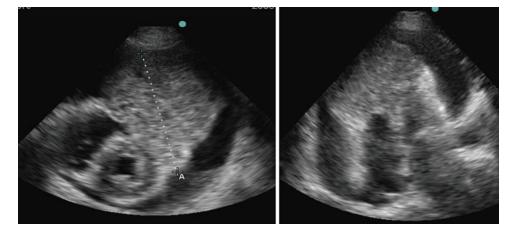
Transthoracic echocardiography. Large sarcoma infiltrating the anteroseptal and apical wall of both left and right ventricles, with massive pericardial effusion
